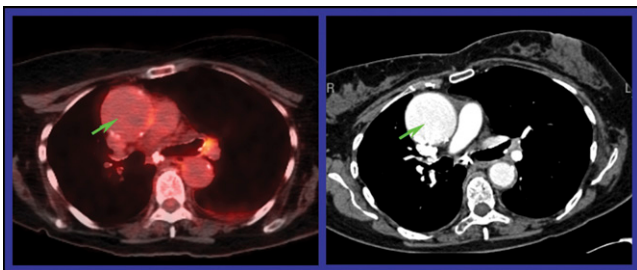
Retrospective review of PET/CT studies revealed incidental aortic aneurysms in 2.3% of patients. In this patient with a 5.8-cm ascending aortic aneurysm, absence of thrombus as indicated by a lack of a cold region within the lesion on PET (left) was confirmed on contrast CT (right).
